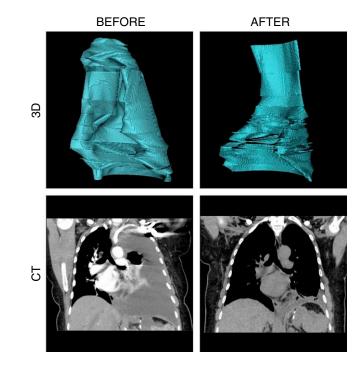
Pleural effusion volume measured by OsiriX digital analysis program and computed tomography (CT) of the chest before and after tissue plasminogen activator/DNase treatment. 3D = three dimensional.
